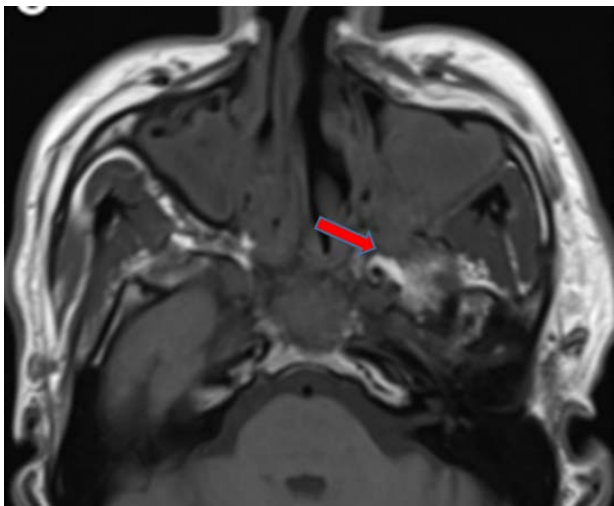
Chronic invasive fungal rhinosinusitis. MRI scan, T1 mode. On the axial section, the pathological process spreads to the pterygopalatine fossa on the left.
